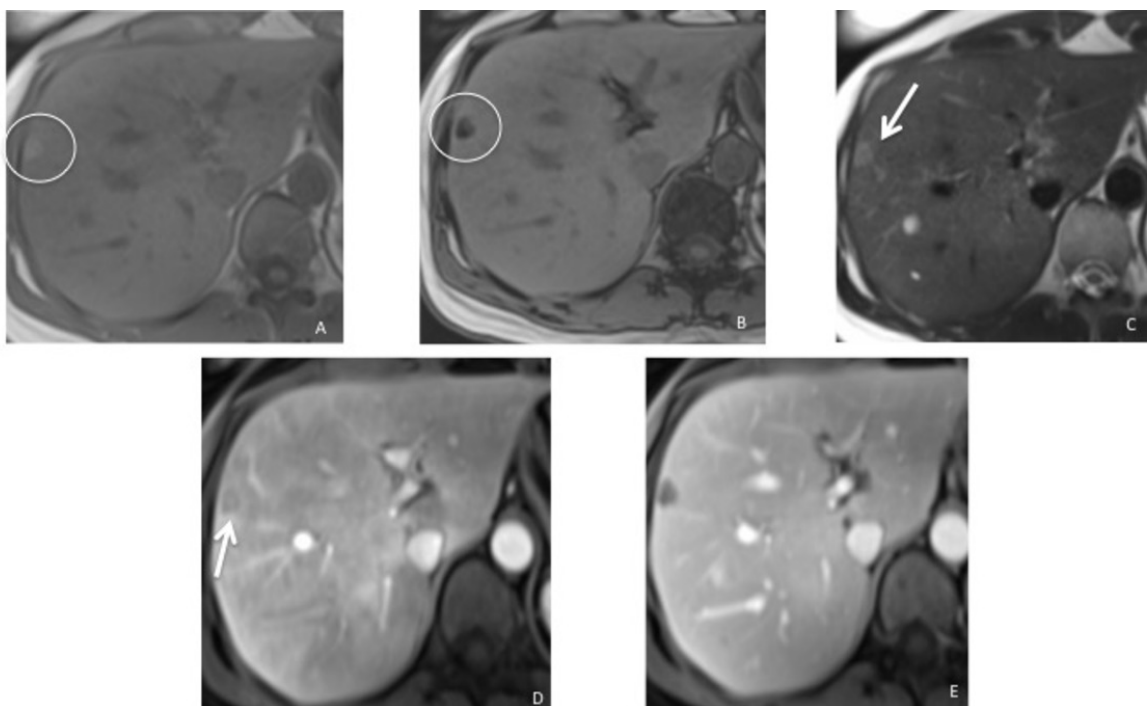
HNF-1 β -mutated hepatocellular adenoma in a 29-year-old woman. Axial T1-weighted in-phase (A) and out-of-phase (B) and T2-weighted (C) MR images depict a focal hepatic lesion that is mildly hyperintense on the T2-weighted image (arrows in C) and mildly hyperintense to the liver on the T1-weighted in-phase image (A), with signal loss on the out-of-phase image (B). Contrast-enhanced T1-weighted MR images obtained in the arterial (D) and portal venous (E) phases show that the lesion has mild enhancement in the arterial phase (arrow in D), which does not persist into the portal venous phase (E).
